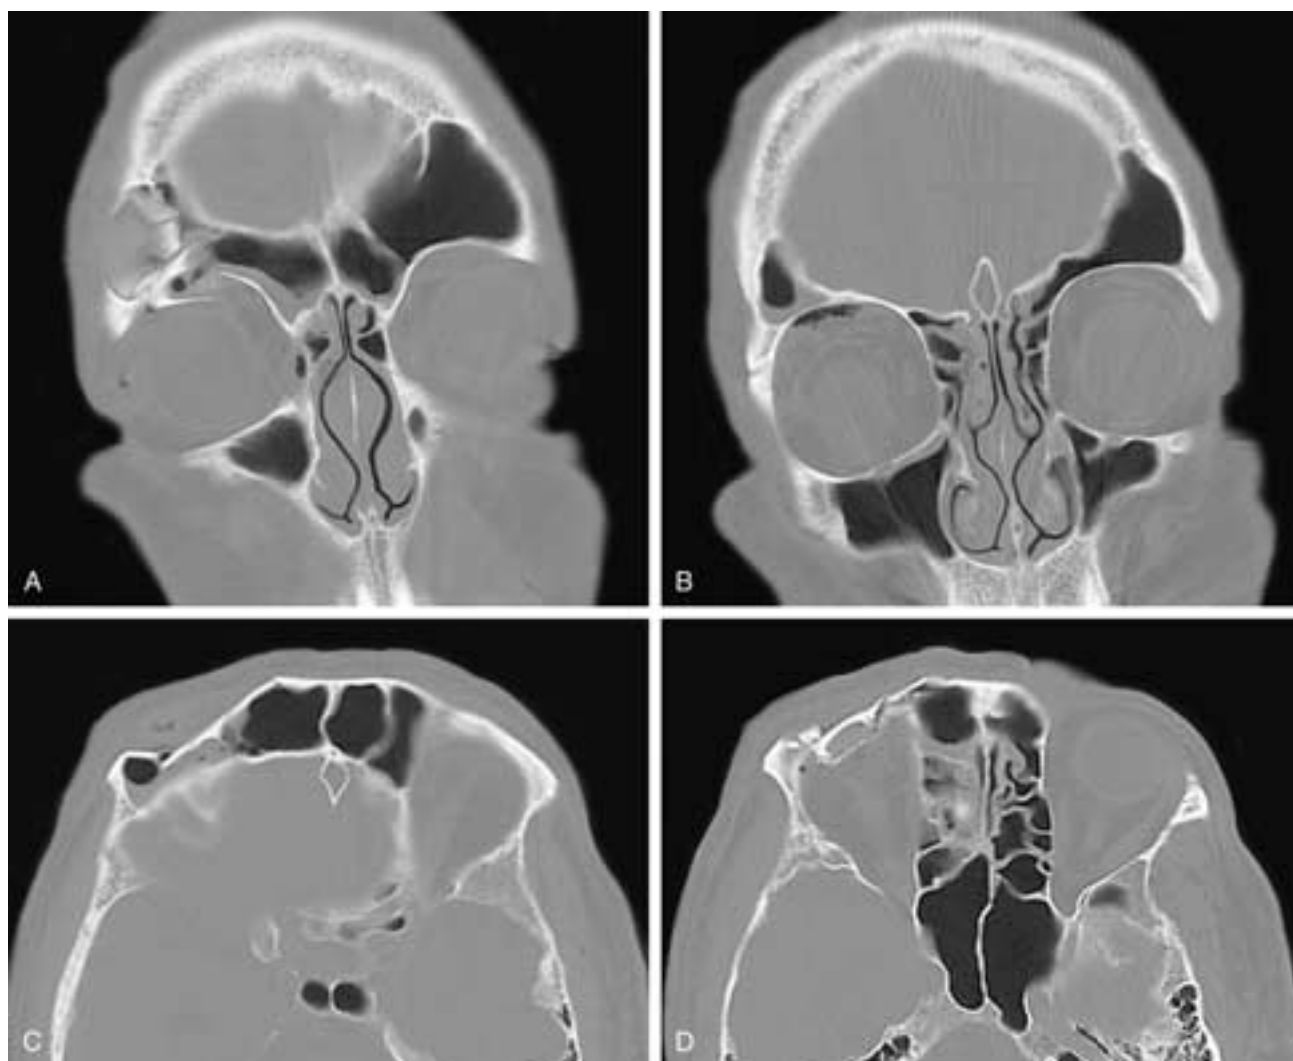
Coronal anterior (A) and posterior (B) CT scans and axial cranial (C) and caudal (D) CT scans show a comminuted right frontal sinus fracture that involves the anterior table and the roof of the orbit. A fracture segment impinges on the upper globe and prevents upward gaze. Orbital emphysema is also present.
